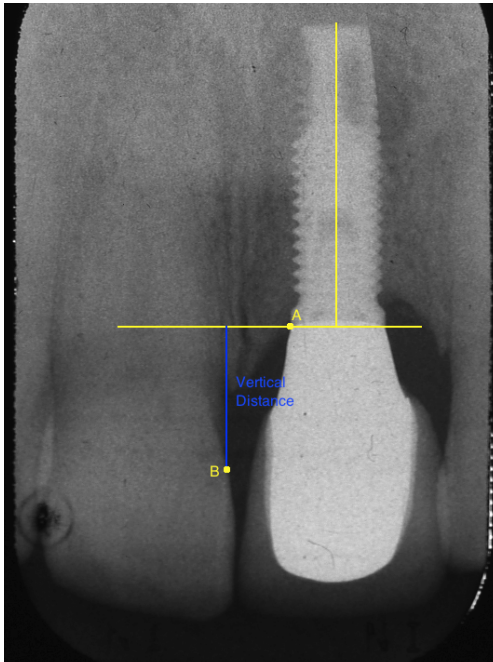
Radiographic assessment of implant infra-occlusion over time. The vertical distance was measured in mm between A (implant-abutment junction) and B (CEJ of the adjacent mesial tooth). The same measurement was performed on the radiograph taken at each follow-up examination. The amount of infra-occlusion (in mm) was calculated based on the difference between the baseline and follow-up measurements.
